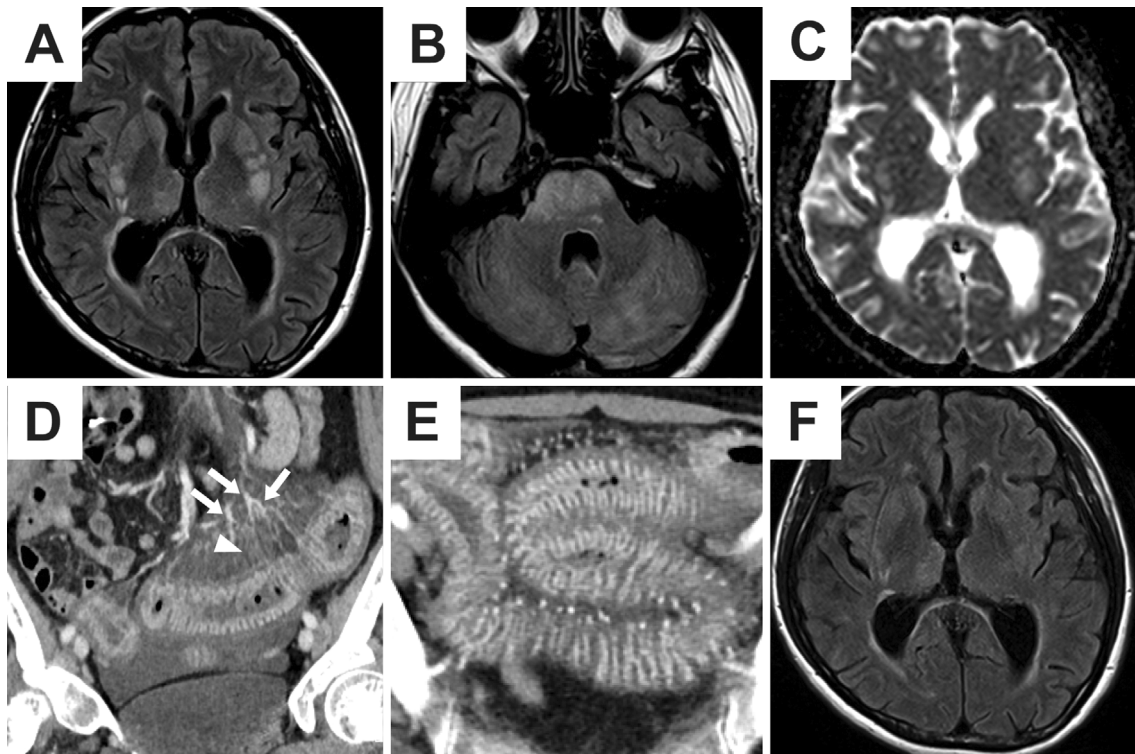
FLAIR brain images (A, B) on admission show hyperintense lesions in the bilateral basal ganglia (A), brainstem, and cerebellum (B). An ADC map (C) on admission shows increased values in the areas of FLAIR abnormalities. Coronal (D) and axial (E) sections of enhanced abdominal computed tomography on the 4th hospital day reveal diffuse wall thickening with intestinal mucosal enhancement and vasa recta engorgement (arrowhead) as well as dilation of the mesentery blood vessels (arrows) and ascites. Six days after initiation of antihypertensive therapy, the FLAIR hyperintense lesions in the bilateral basal ganglia are markedly decreased (F). FLAIR: fluid attenuated inversion recovery
